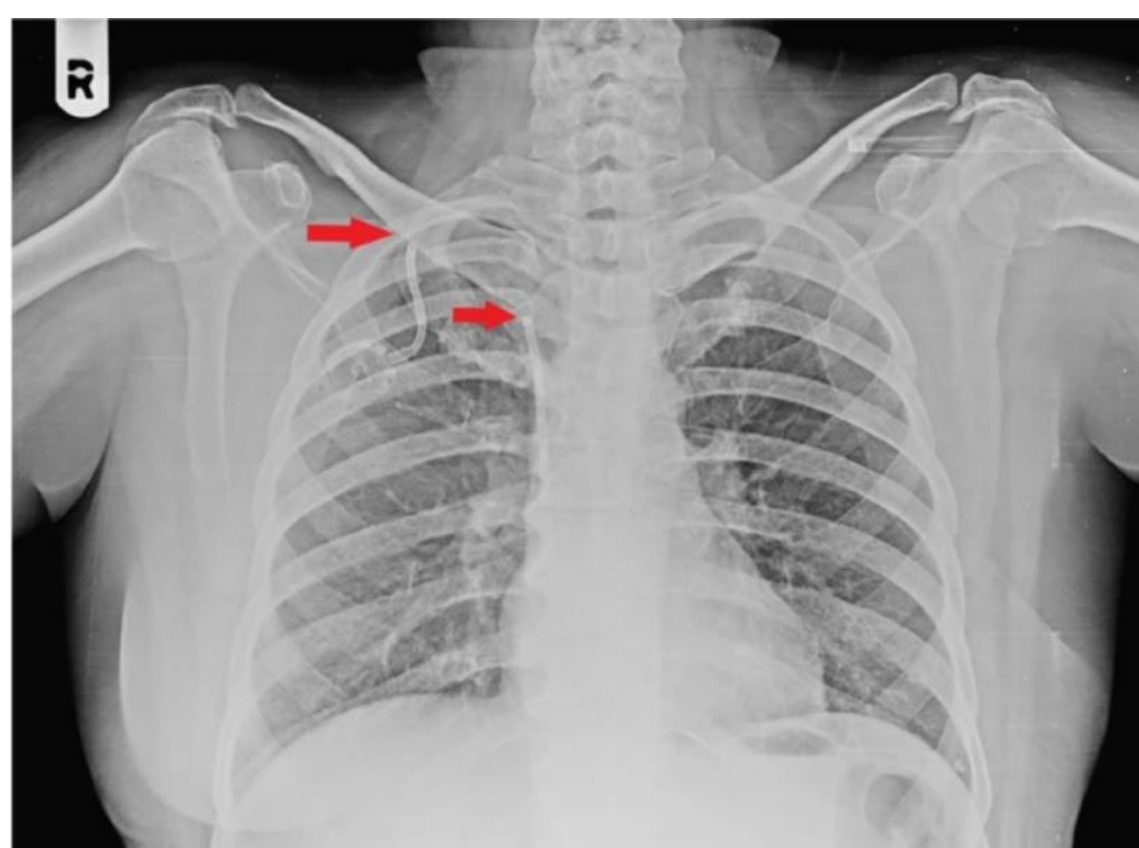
X-ray image of Pinch-Off Syndrome of patient with CVC inserted using subclavian approach. Arrows indicate two ends of fractured catheter⁷.
